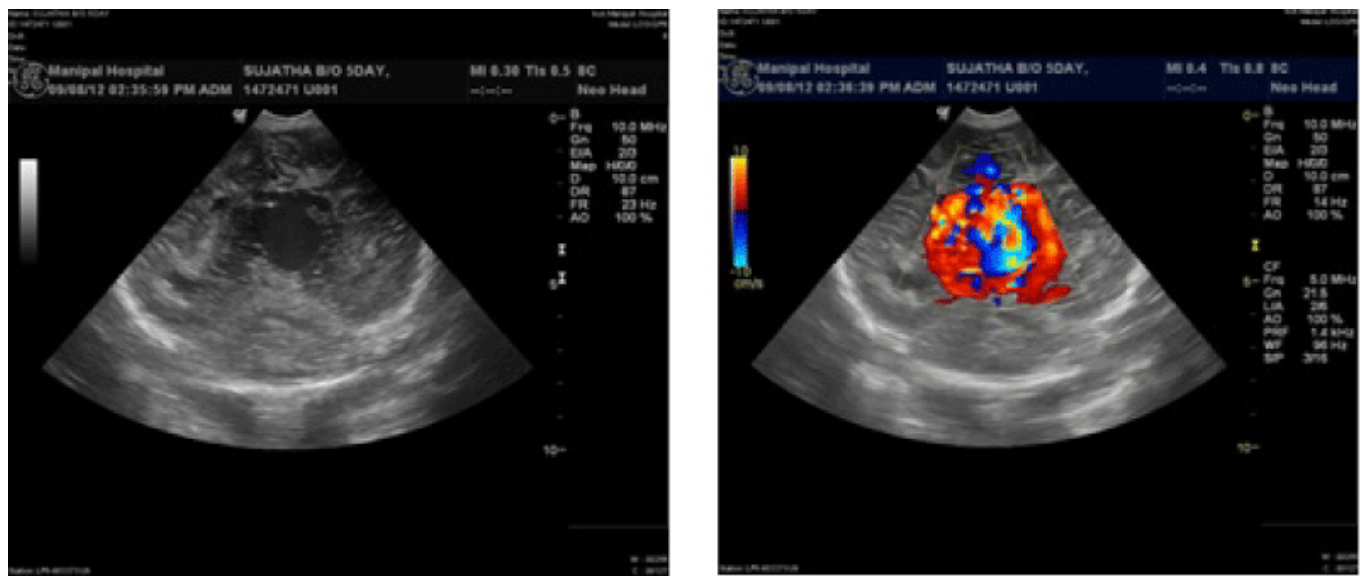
2D and Doppler images showing Vein of Galen malformation with feeding vessels
